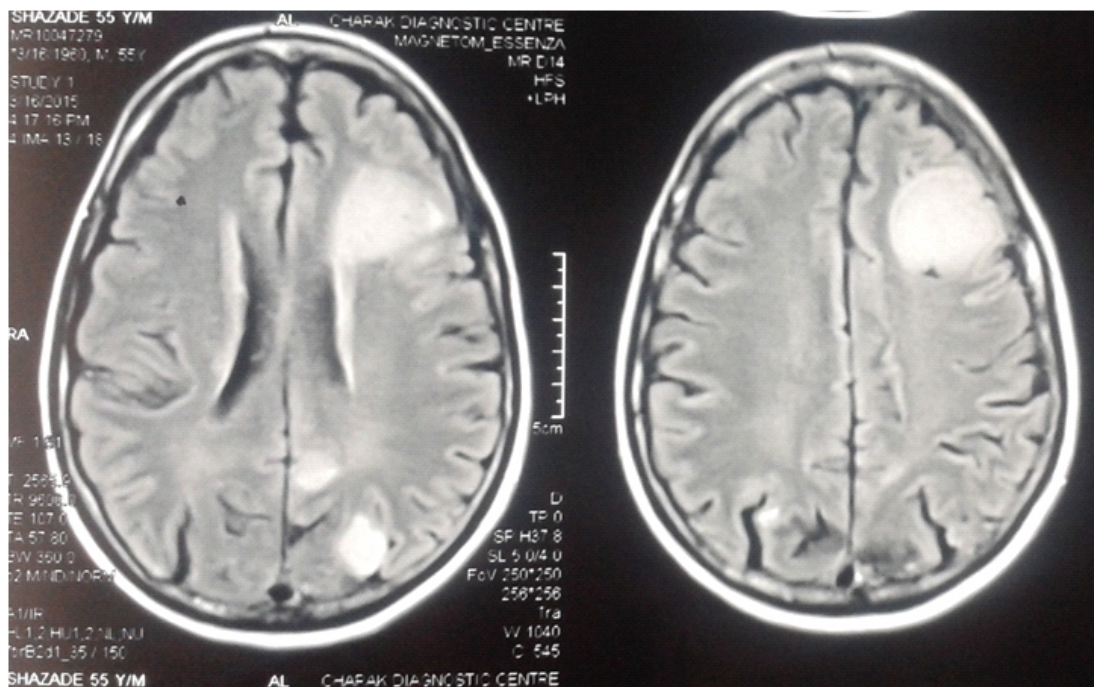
MRI brain showing multiple metastatic lesions with surrounding edema (T2 flair axial)
